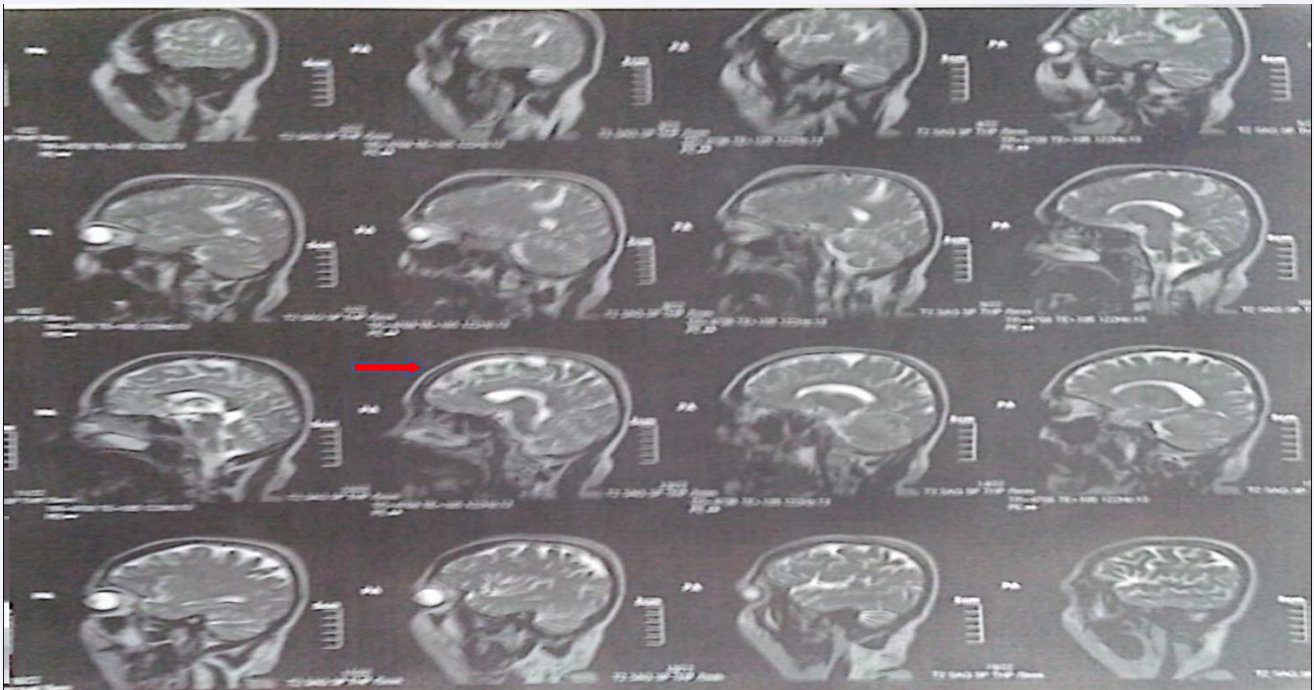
Brain MRI showing high T2 signal intensity in the right parietal subcortical area (red arrow)
